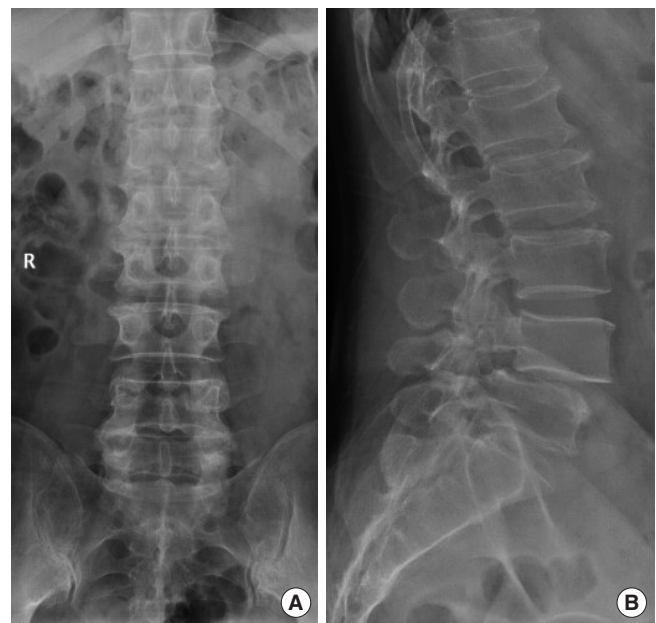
Standing nonfunctional anterior-posterior (A) and lateral x-ray images (B) of single-level degenerative lumbar spondylolisthesis.
